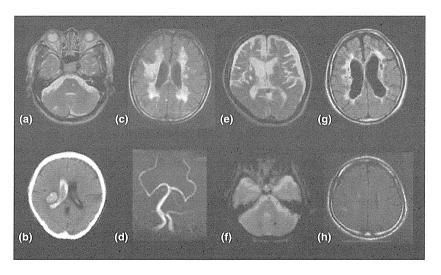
Brain MRI and CT findings of patients with *GLA* p.E66Q. (a, b) Patient 1. T2-weighted MRI showed small-vessel occlusions in the right cerebellar hemisphere and pons (a). Brain CT showed large left thalamic hematoma with rapture into the lateral ventricle (b). (c, d) Patients 2. Fluid-attenuated inversion recovery (FLAIR) MRI showed multiple small-vessel occlusions accompanied by marked leukoaraiosis (c). Magnetic resonance angiography (MRA) showed moderate dolichoectasia of the basilar and vertebral arteries (d). (e, f) Patient 3. T2- (e) and T2*-weighted (f) MRI showed multiple small-vessel occlusions and microbleeds in the cerebral white matter and basal ganglia. Microbleeds were also observed in the dentate nucleus. (g, h) FLAIR MRI of patient 4 (g) and patient 5 (h) showed multiple small-vessel occlusions in the cerebral white matter. Leukoaraiosis was also observed in patient 4 (g).
